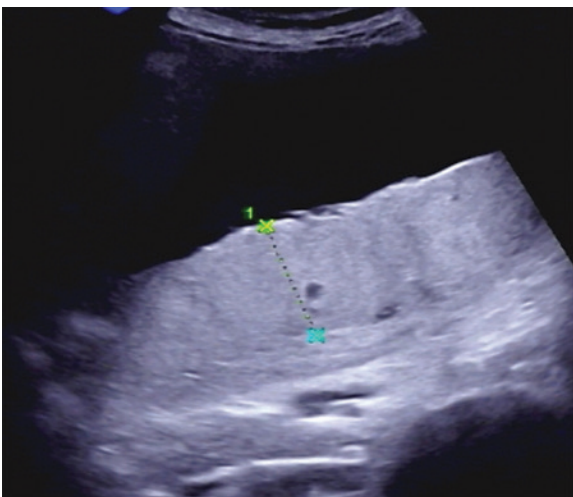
Obstetric ultrasound: polyhydramnios.
